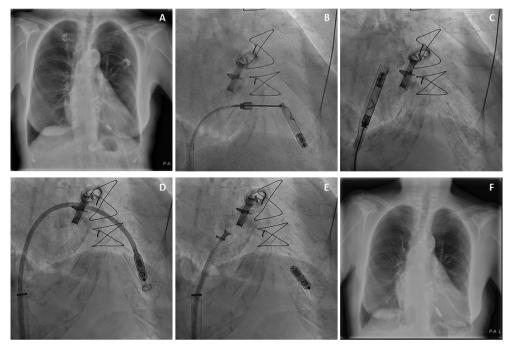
A: Chest radiography of the Nanostim, B: capture of the distal cap of the device by the snare at the end of the retrieval catheter, C: Nanostim removal from the RV, D: Micra insertion in the RV, E: Micra fixation in the right ventricular myocardium at a slightly different location (i.e. more septal) with the nitinol tines, F: Chest radiography of the Micra.
